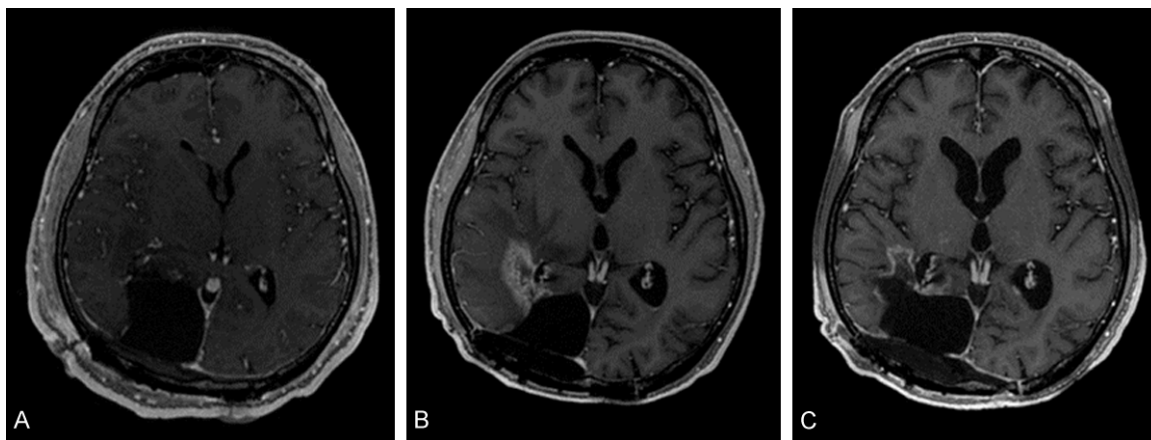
Postoperative MRI (contrast-enhanced T1-weighted images). A. The postoperative partial defect in the right occipital lobe is seen. B. Fifteen months after the operation, a small, enhancing nodular lesion has appeared at the operation site. C. Three and a half years after the operation, multiple, small enhancing lesions have emerged on the lateral ventricular wall.
